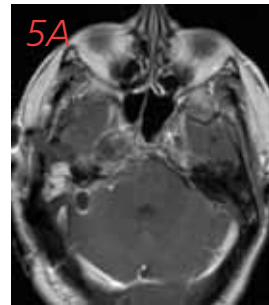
Postoperative contrasted magnetic resonance images in axial (A) and coronal (B) planes showing decompression of the brainstem and near-total removal of the tumor from within the petrous bone.
